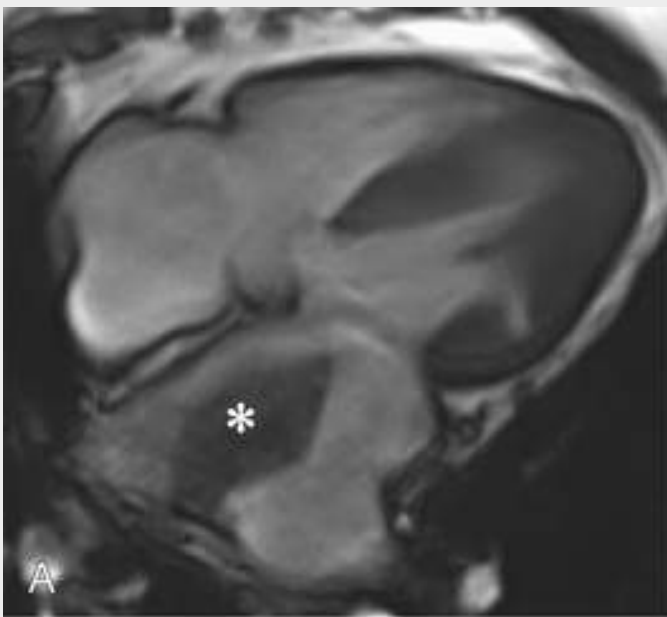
A 66-year-old woman with factor V Leiden mutation and antiphospholipid syndrome was found to have a mass on echocardiography and was then referred for CMR evaluation. A, SSFP image, four-chamber view, demonstrates an isointense mass in the left atrium posterior wall (*asterisk*). B, T1-weighted double-inversion recovery (DIR) image, short-axis view, shows an isointense mass attached to the left atrial wall (*arrows*). There is another small mass in the posterior wall of the atrium (*asterisk*). C, On LGE image, short-axis view, the mass appears to be heterogeneously hyperintense. D, However, on LGE, long inversion time (TI) image (600 msec), short-axis view, the mass was nulled completely, suggesting lack of enhancement. These findings are consistent with an intracardiac thrombus.
